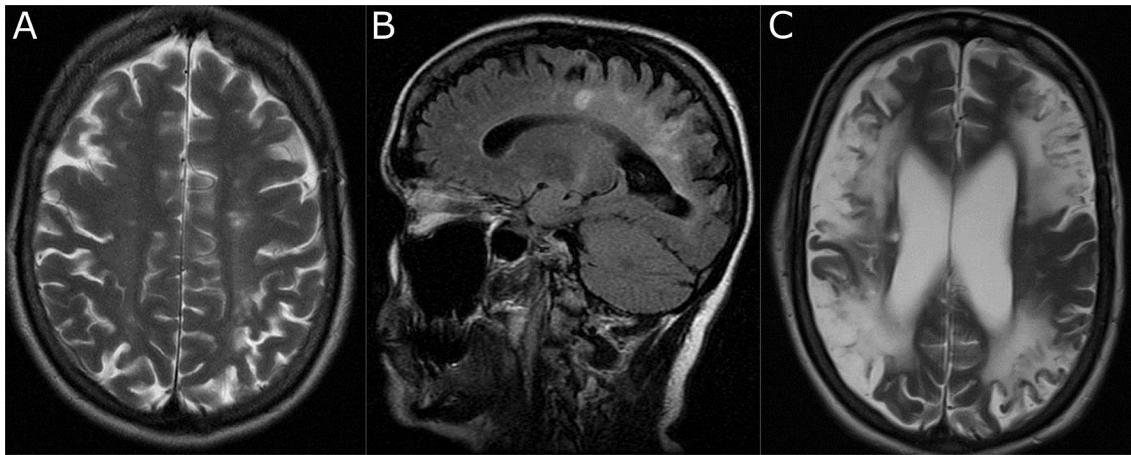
MRI of a 30 year-old female patient in 2008 a, b misdiagnosed as MS despite negative oligoclonal banding in CSF and treated with beta interferons for years. c The MRI after recurrent strokes in 2014
